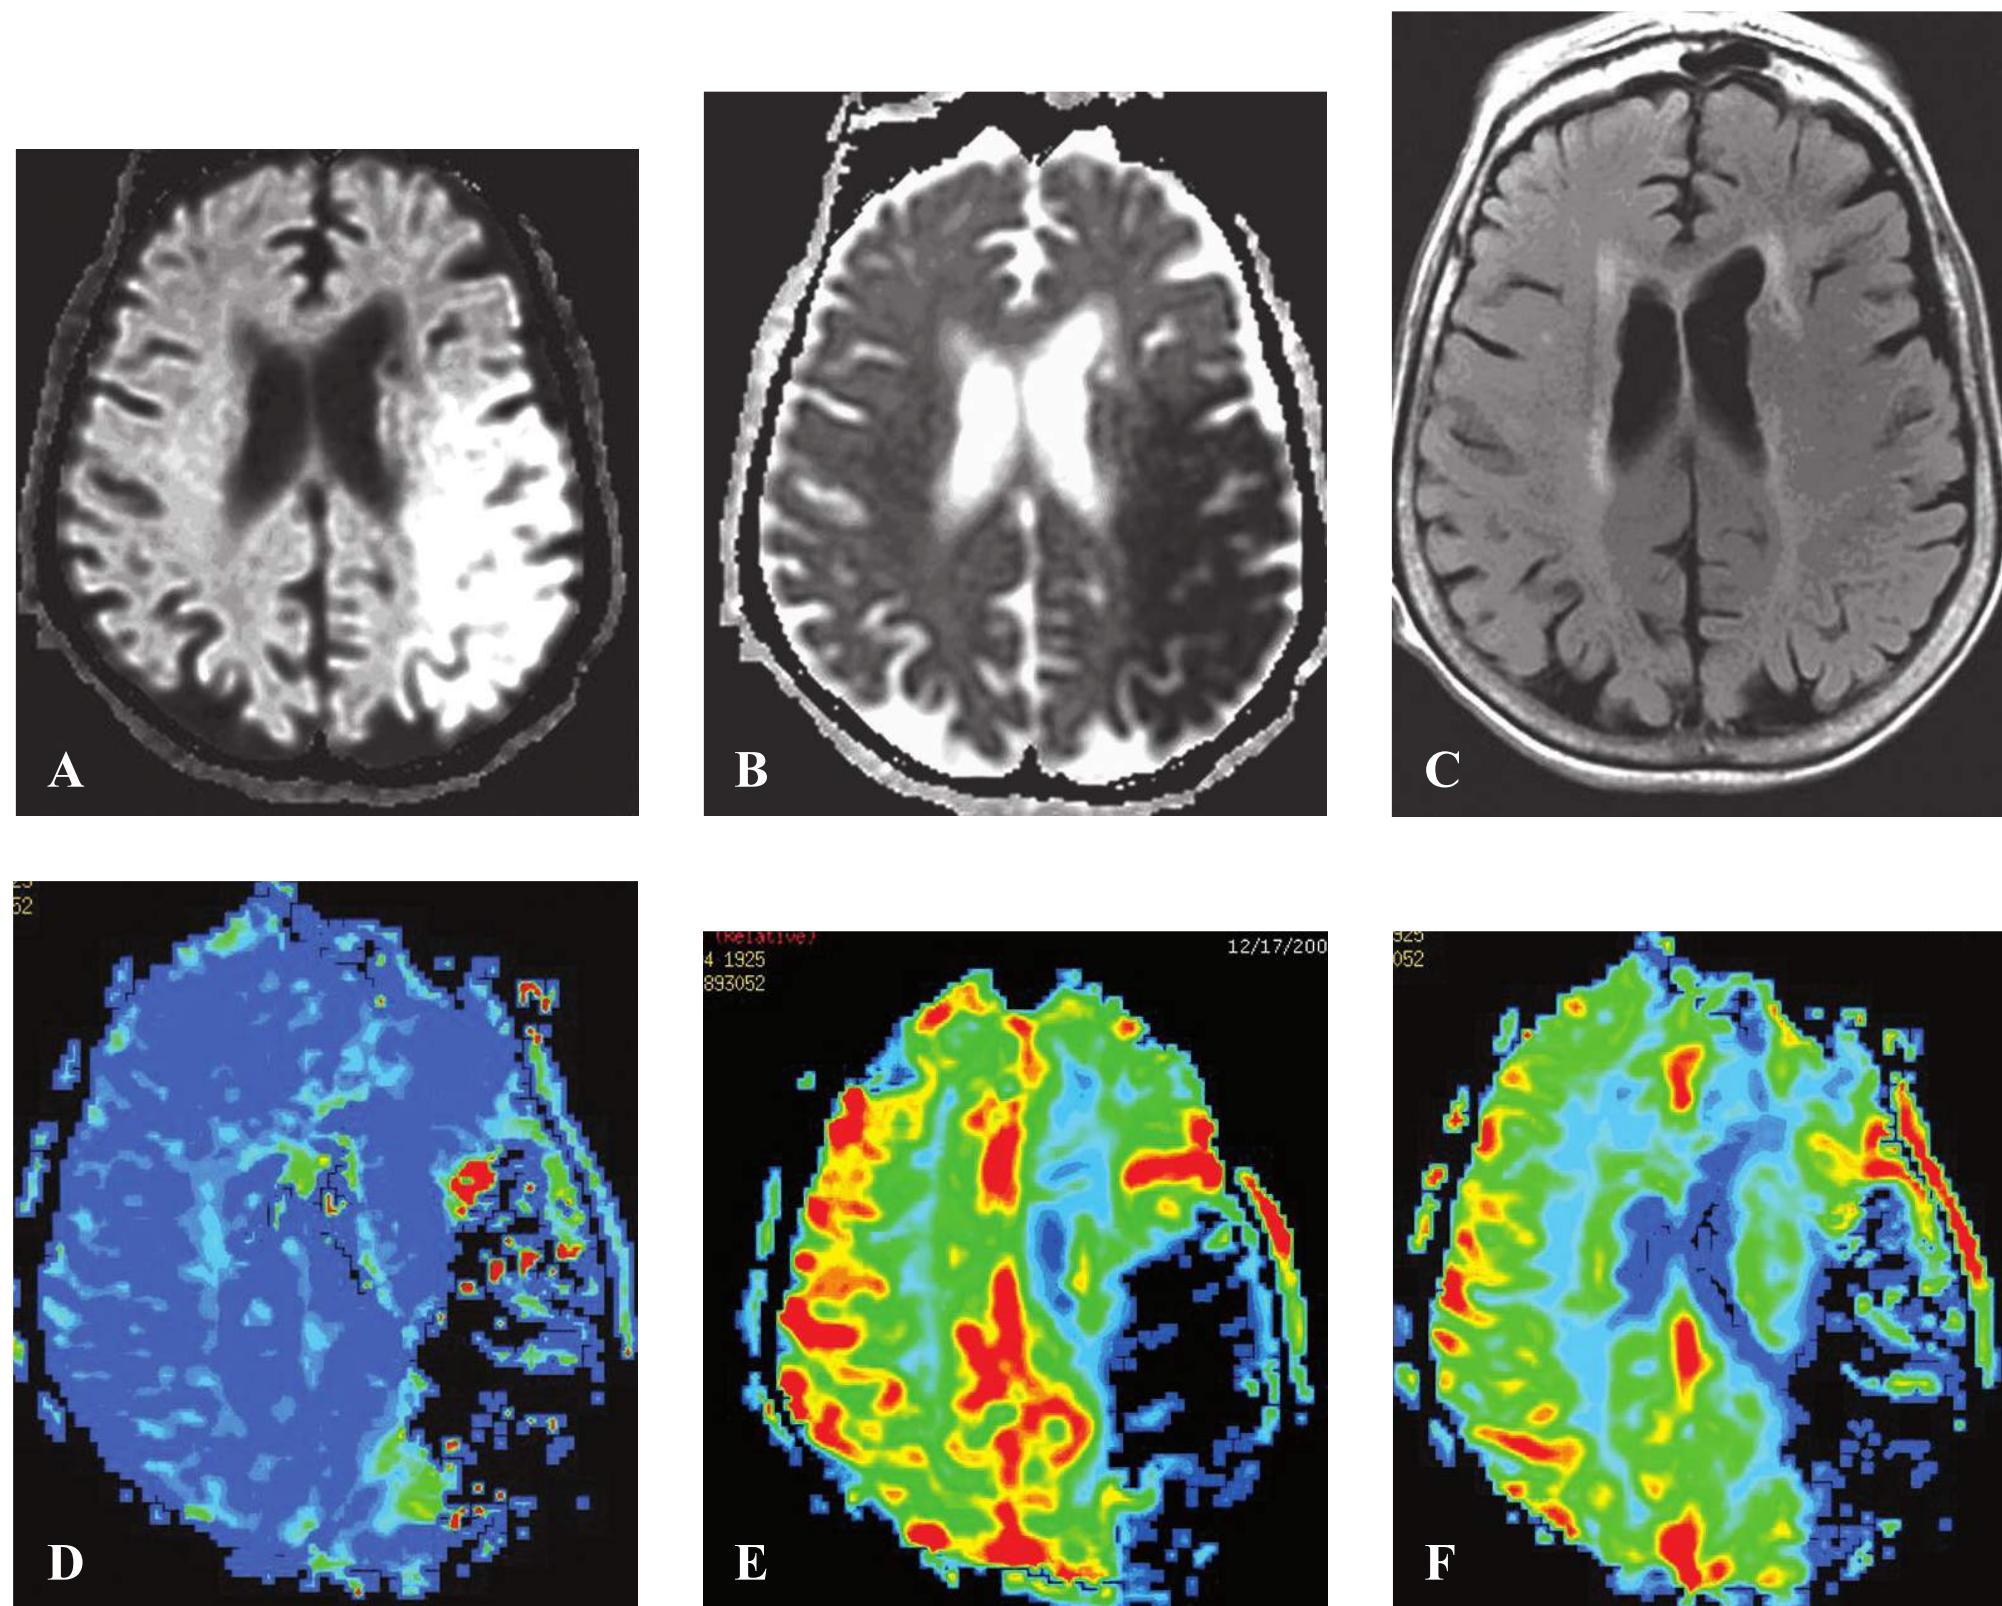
(A–F) Matched diffusion–perfusion defect. This patient is not a candidate for interventional or arguably intravenous thrombolysis because the area of infarction (hyperintense on DWI) matches the area of perfusion defect, making this a “completed infarction” in this 84-year-old woman with sudden-onset aphasia, right hemiplegia, right hemisensory loss, and right homonymous hemianopsia in the context of atrial fibrillation.
